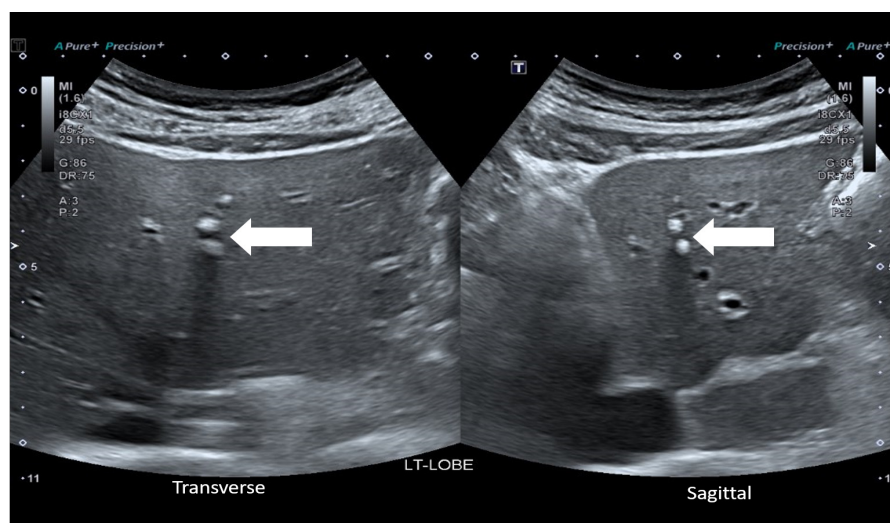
Sonographic Image Displaying a Calcified Granuloma Characterized by Hyperechoic Nodules with Posterior Acoustic Shadows (arrow).
